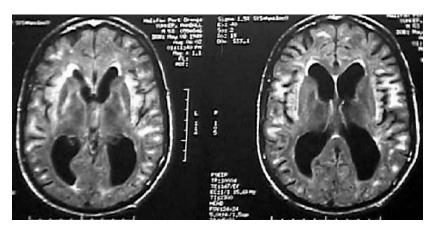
Flair magnetic resonance images revealed prominent white matter hyperintensites in the frontal and parietal regions with posterior ex vacuo dilatation of his lateral ventricles.
